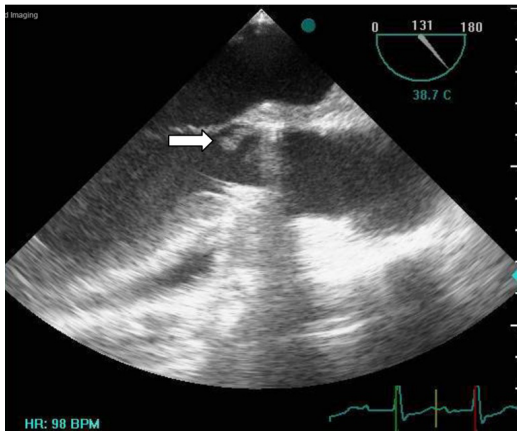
The vegetation was presented underneath the aortic valve, in size of 1 x 0.5 cm (arrow), in transesophageal echocardiography.
